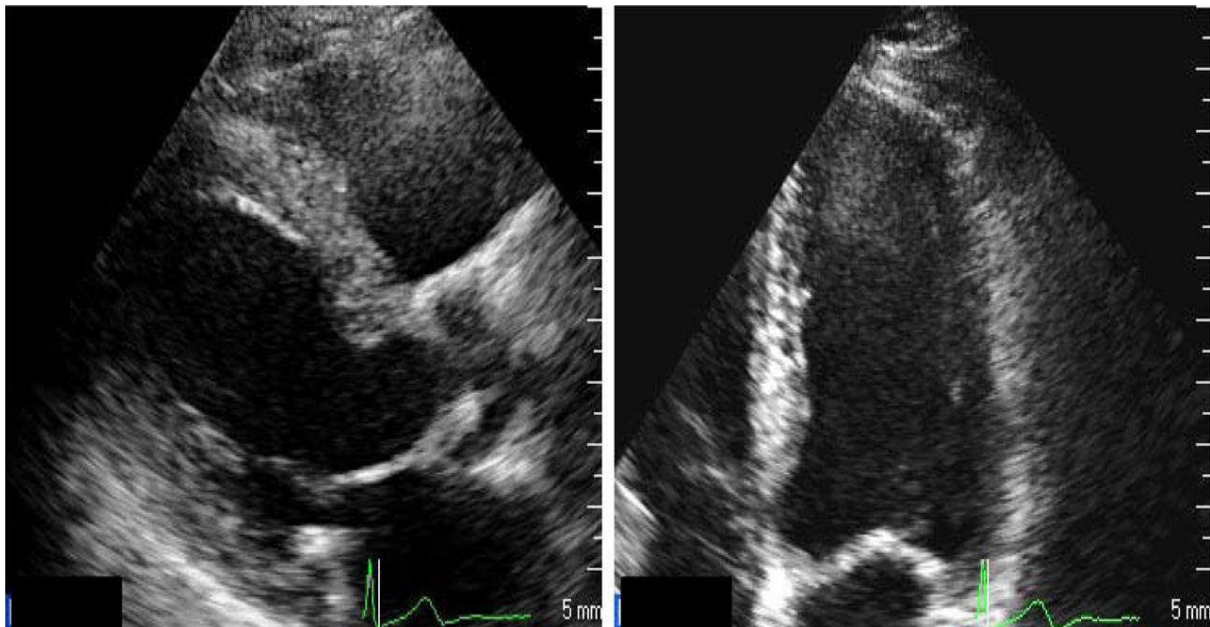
A parasternal long-axis (left) and apical four-chamber views (right) from a 55-yearold showing concentric left ventricular hypertrophy
